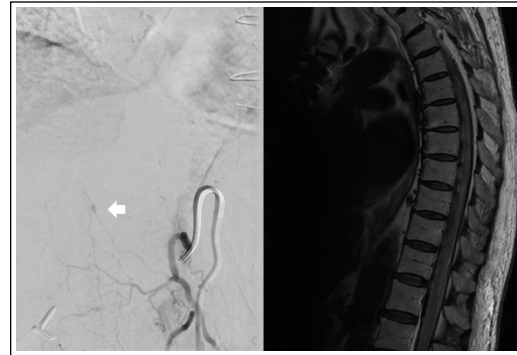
DSA with aneurysmal segment of a small feeder vessel to the posterior medullary artery. MRI sagittal T2 sequence with extensive blood products.
